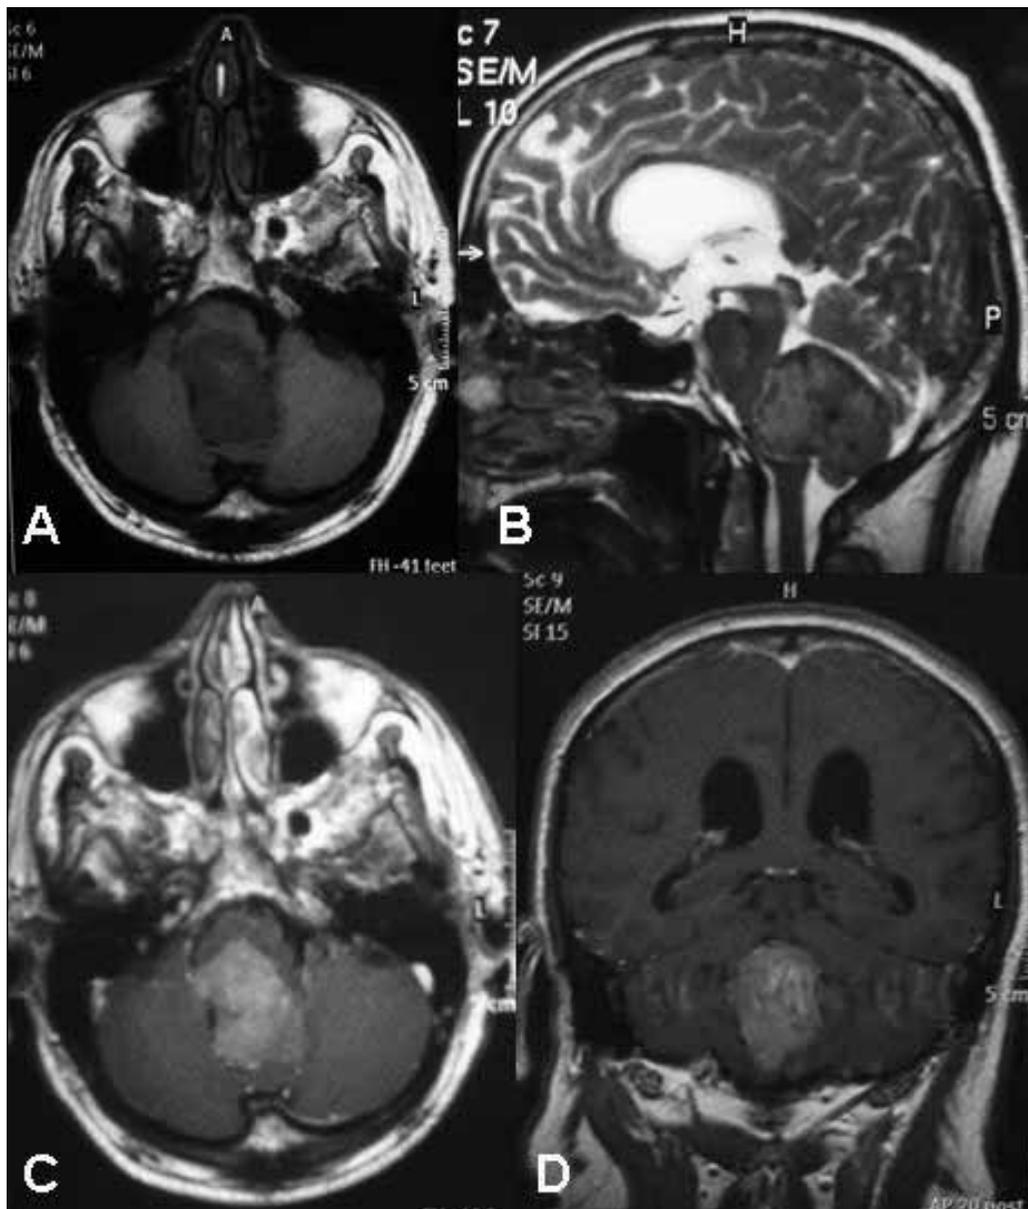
Pre-operative cranial MRI of the patient in our case, demonstrating a mass lesion in the fourth ventricle with brain stem compression, and obstructive hydrocephalus. A) axial T1-weighted, B) sagittal T2-weighted, C) axial post-contrast, and D) coronal post-contrast images.
